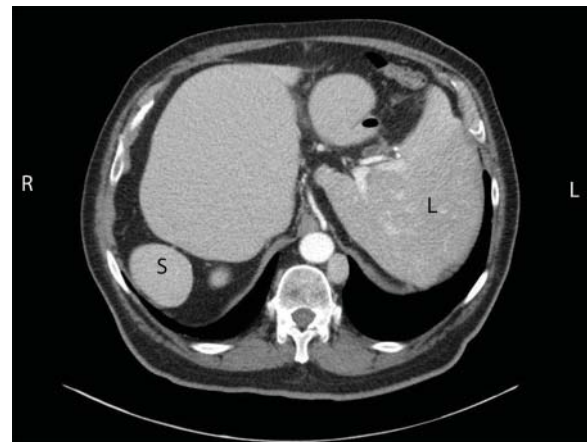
Computed tomography of the abdomen confirmed situs inversus totalis, with the liver (L) on the left side and the spleen (S) on the right side.
